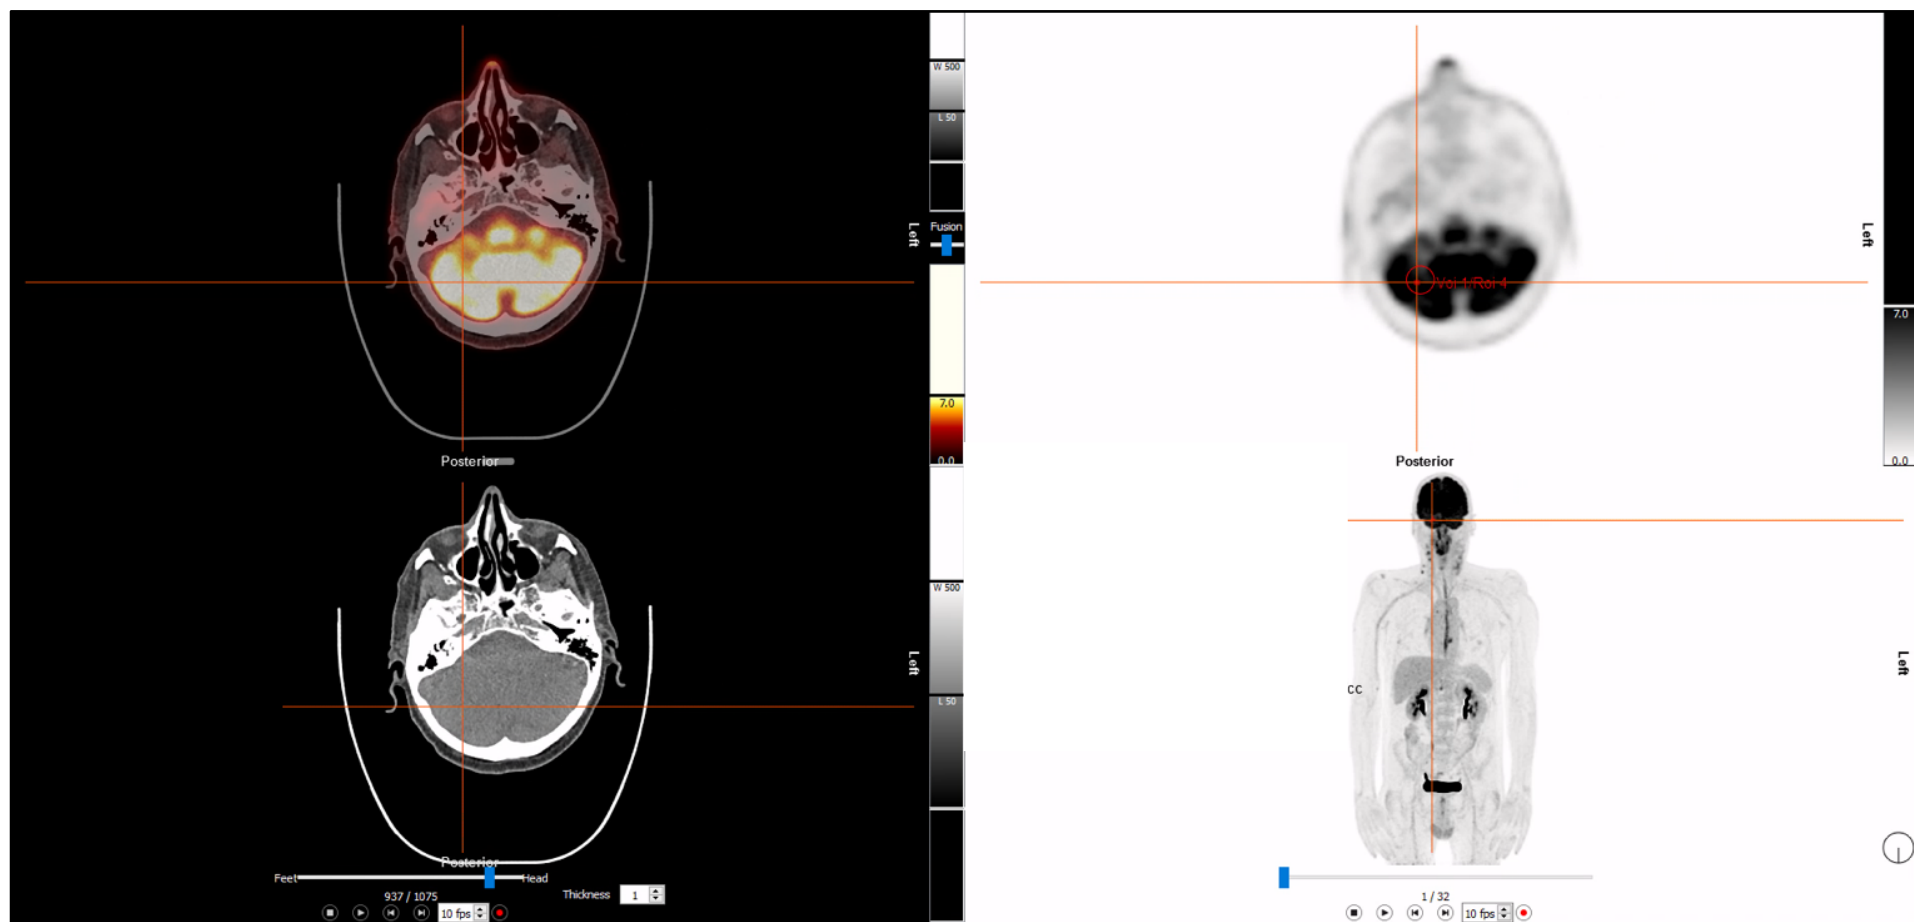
$SUV_{mean}$  and  $SUV_{max}$  derived from a fixed-size VOI drawn over the cerebellum.
